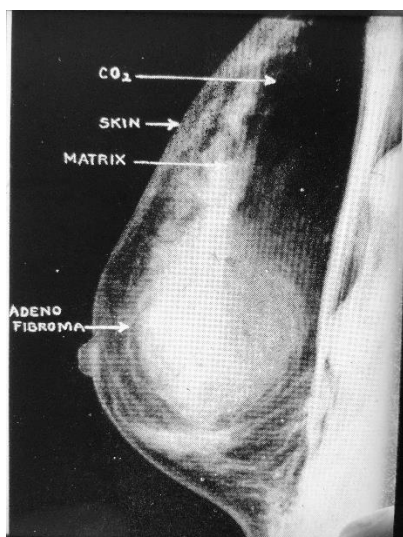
Pneumo-mammography/Roentgen Pneumastasia. The central mass, a fibroadenoma, is outlined with the carbon dioxide injected into the breast.
